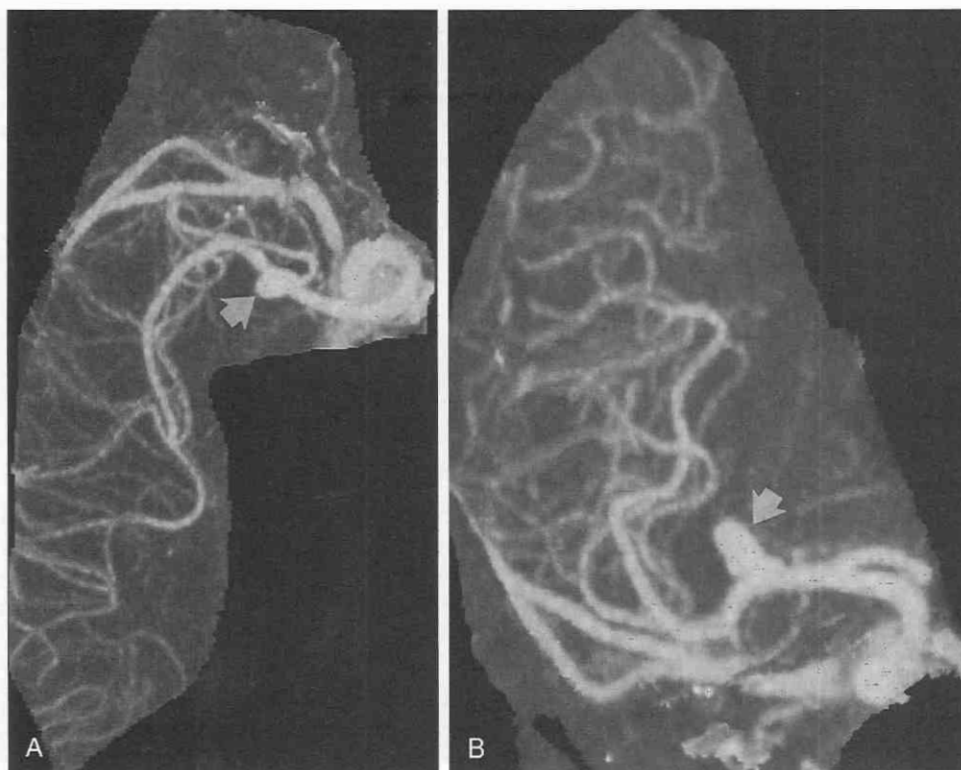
Middle cerebral artery aneurysm in a 60-year-old man who presented with headaches. Multislice helical CT was performed with a slice width of 0.5 mm and a reconstruction increment of 0.2 mm. Maximum-intensity projection axial (A) and oblique (B) images show a middle cerebral artery aneurysm (arrows).
